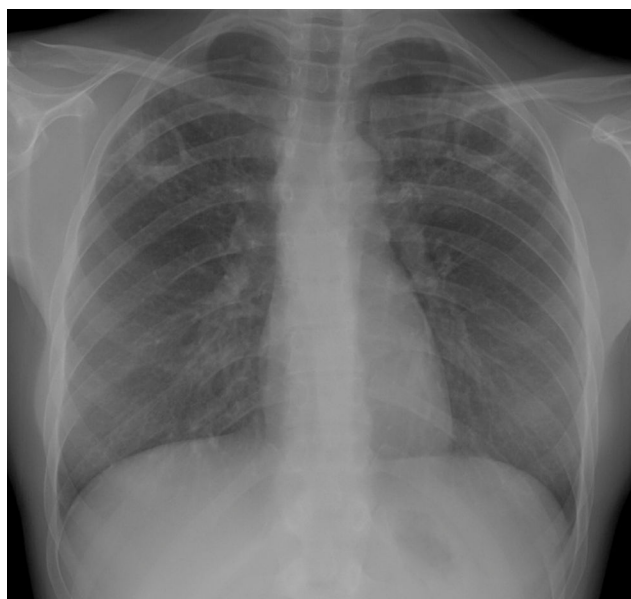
Radiographs showing tuberculous cavities in both upper fields.
